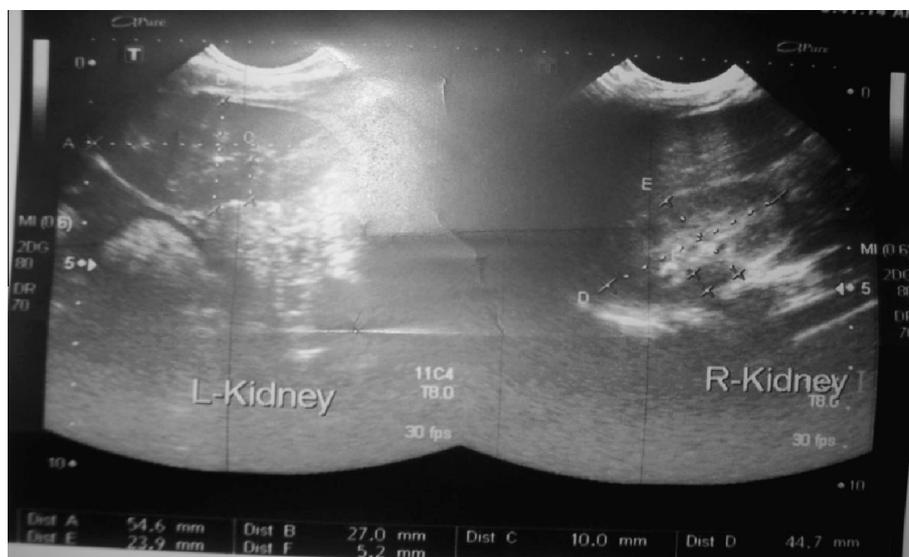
Abdomino-pelvic ultrasonography demonstrated bilateral renal stones.
